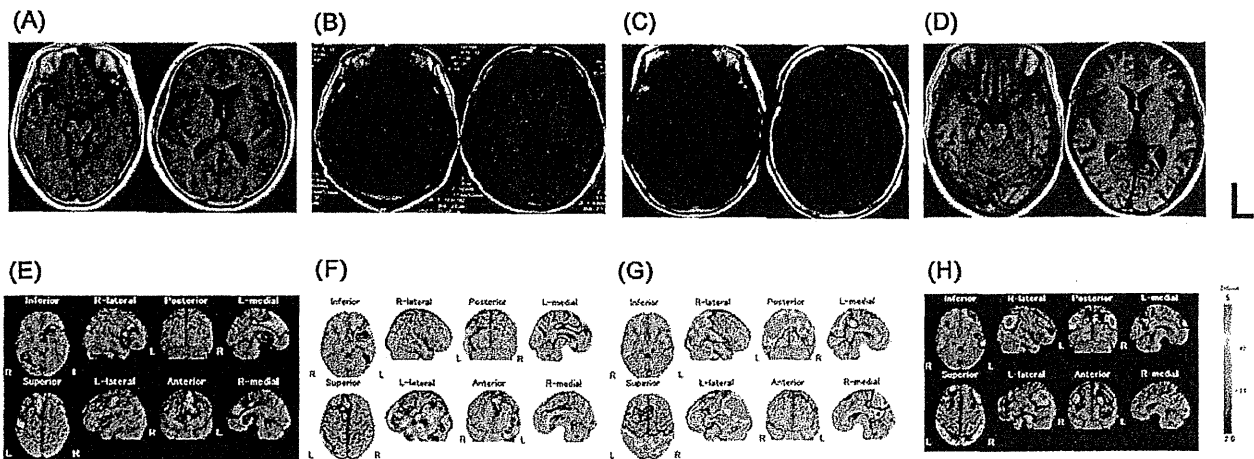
MRI and  $^{99m}\text{Tc}$  ECD-SPECT. Brain MRI of PPA patients for naPPA (A), lvPPA (B), svPPA (C) and early-onset AD (D).  $^{99m}\text{Tc}$  ECD-SPECT of patients for naPPA (E), lvPPA (F), svPPA (G) and AD (H). naPPA is characterized by predominant atrophy (A) and hypoperfusion (E) in the left posterior fronto-insular region, svPPA by predominant atrophy (B) and hypoperfusion in the left anterior temporal lobe (F), and lvPPA by predominant atrophy (C) and hypoperfusion in the left posterior perisylvian or parietal region (G). An early-onset AD patient showed frontal and temporal lobes atrophy (D), and hypoperfusion in the frontal lobes and parietal lobes cortices and the posterior cingulate (H).
